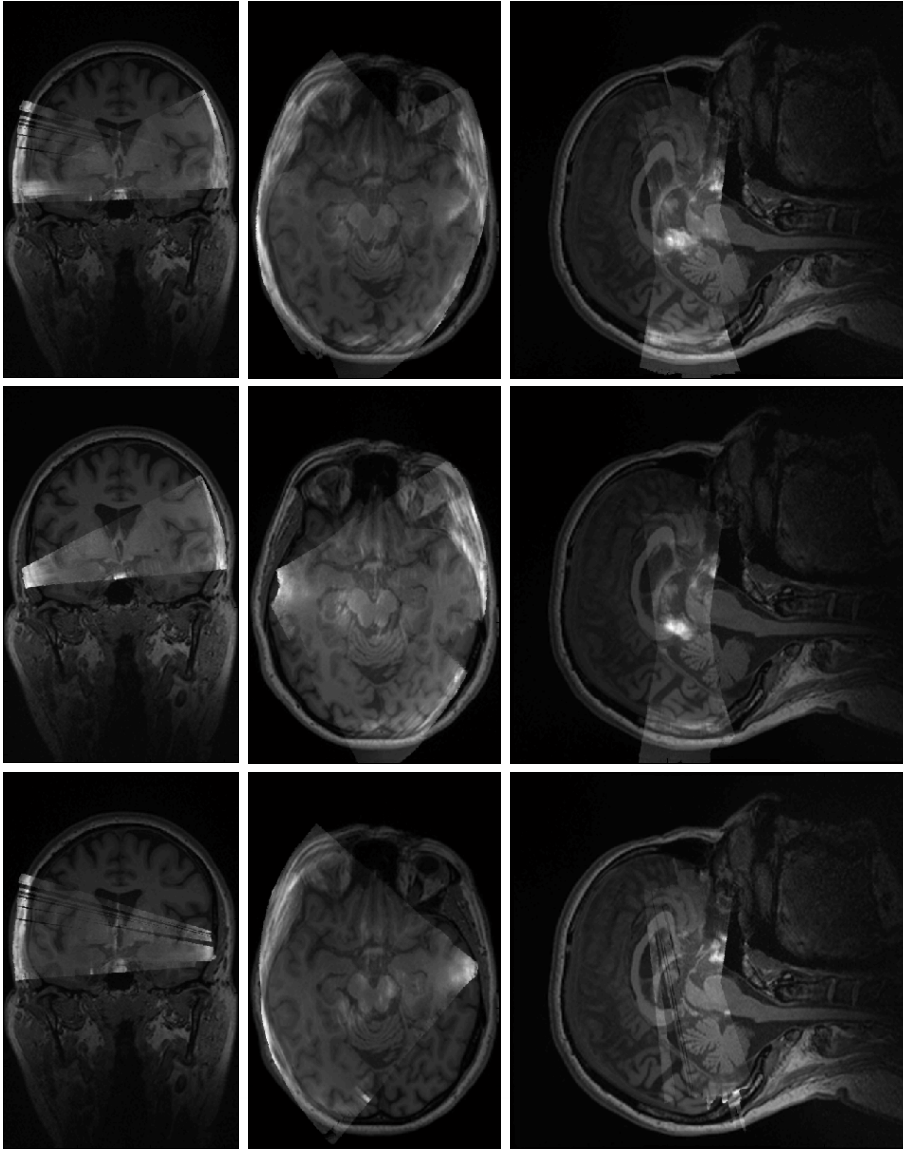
First result from our multi-modal acquisition (one subject shown), with coronal, axial and sagittal views (left, middle, right column). The top row shows an overlay of 3D B-mode US and MRI, with bi-lateral reconstruction. The middle and bottom row show uni-lateral reconstructions from left and right bone window, respectively. Cranial walls seem well-matched between US and MRI (top left), as well as the midbrain (middle, middle).
